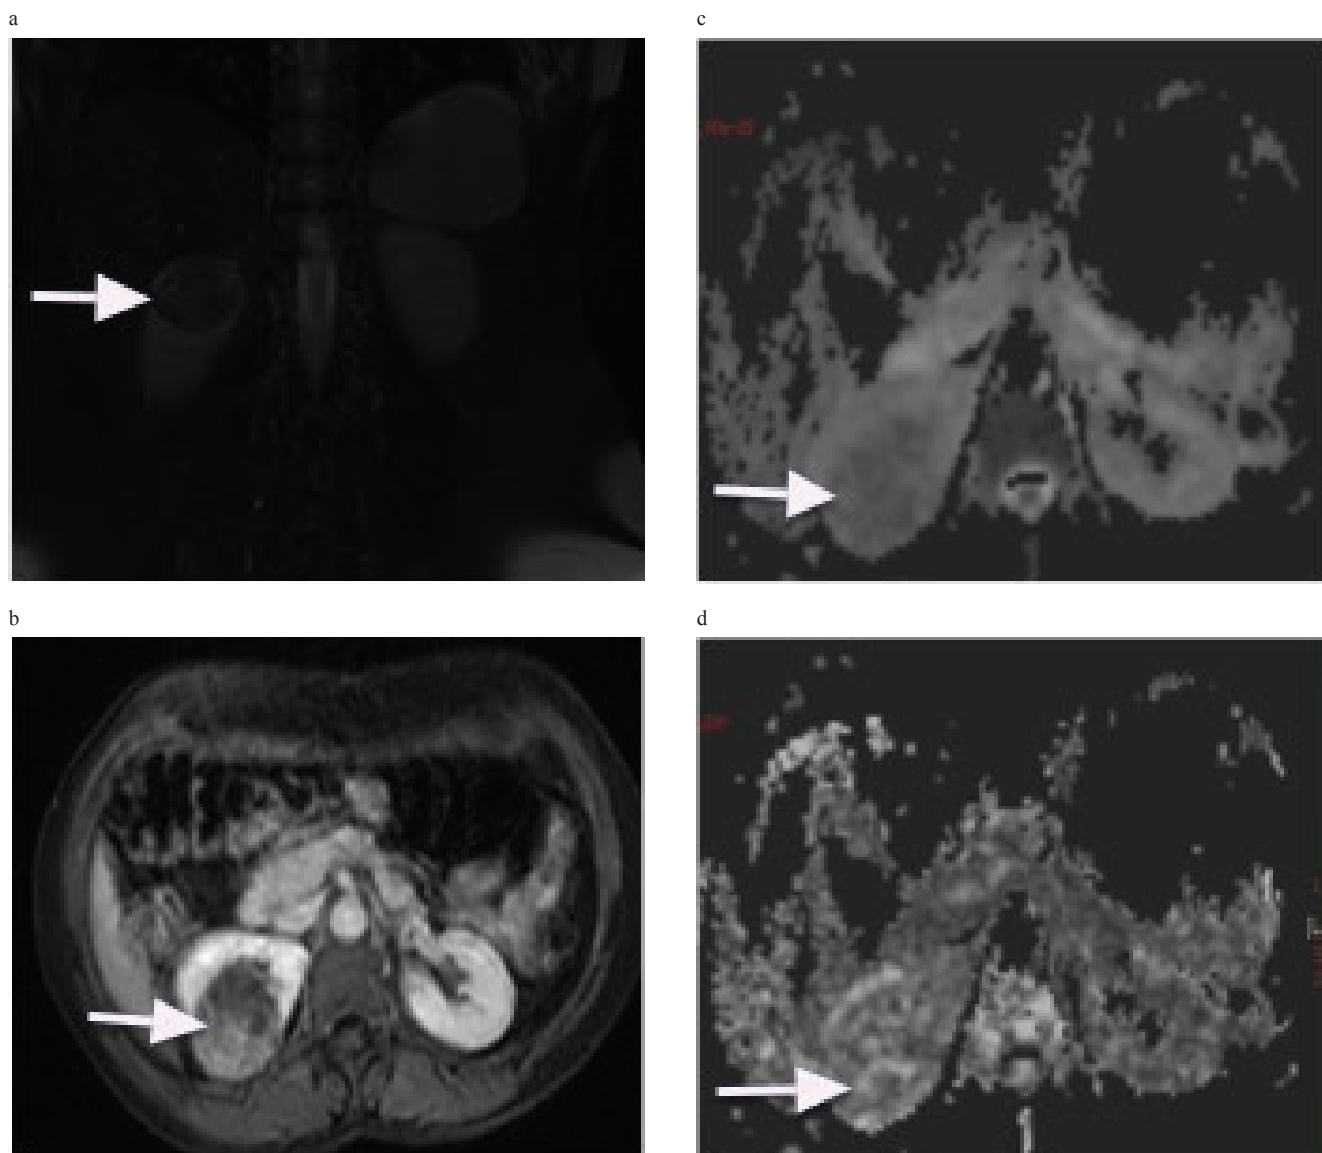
An angiomyolipoma (white arrow) in the right kidney appears as a fat containing lesion on coronal fatsuppressed T2-weighted images (figure 4a). Lesion shows enhancement after gadolinium administration (figure 4b). The angiomyolipoma had an ADC value of $1.38 \times 10^{-3} \text{ mm}^2/\text{s}$ and an Fa value of 0.34. Figures 4c and 4d are ADC and Fa maps, respectively.
